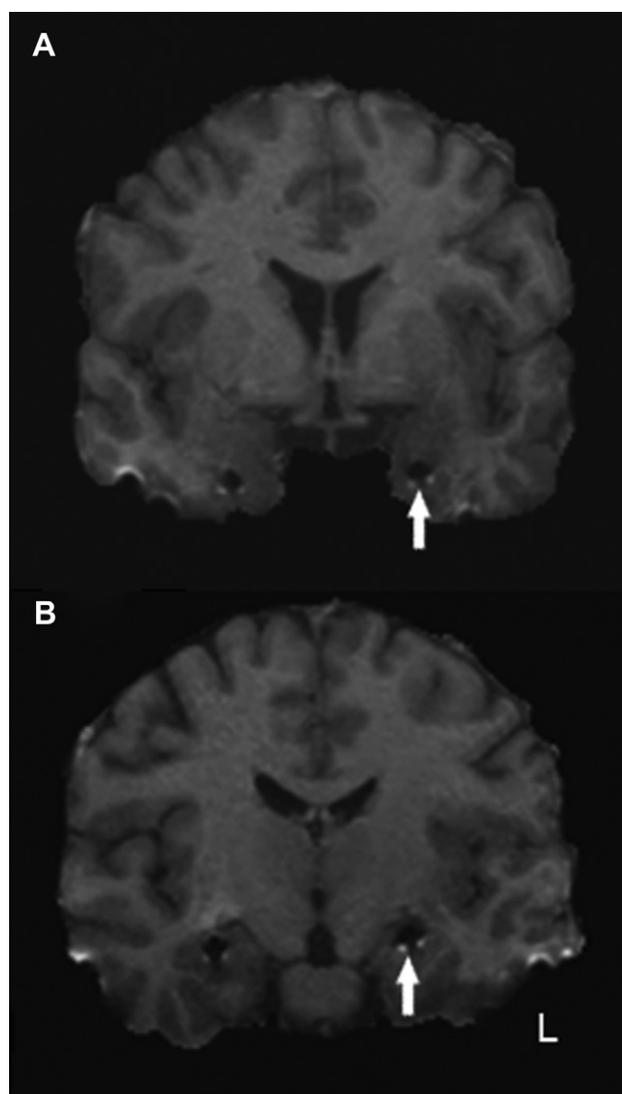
Localization of depth electrode contacts: two coronal MR images of a patient with bilateral depth electrodes in situ (radiological convention, L = left). (A) The white arrow indicates the chosen electrode contact within rhinal cortex. (B) The white arrow designates the chosen electrode contact within the anterior hippocampus.
